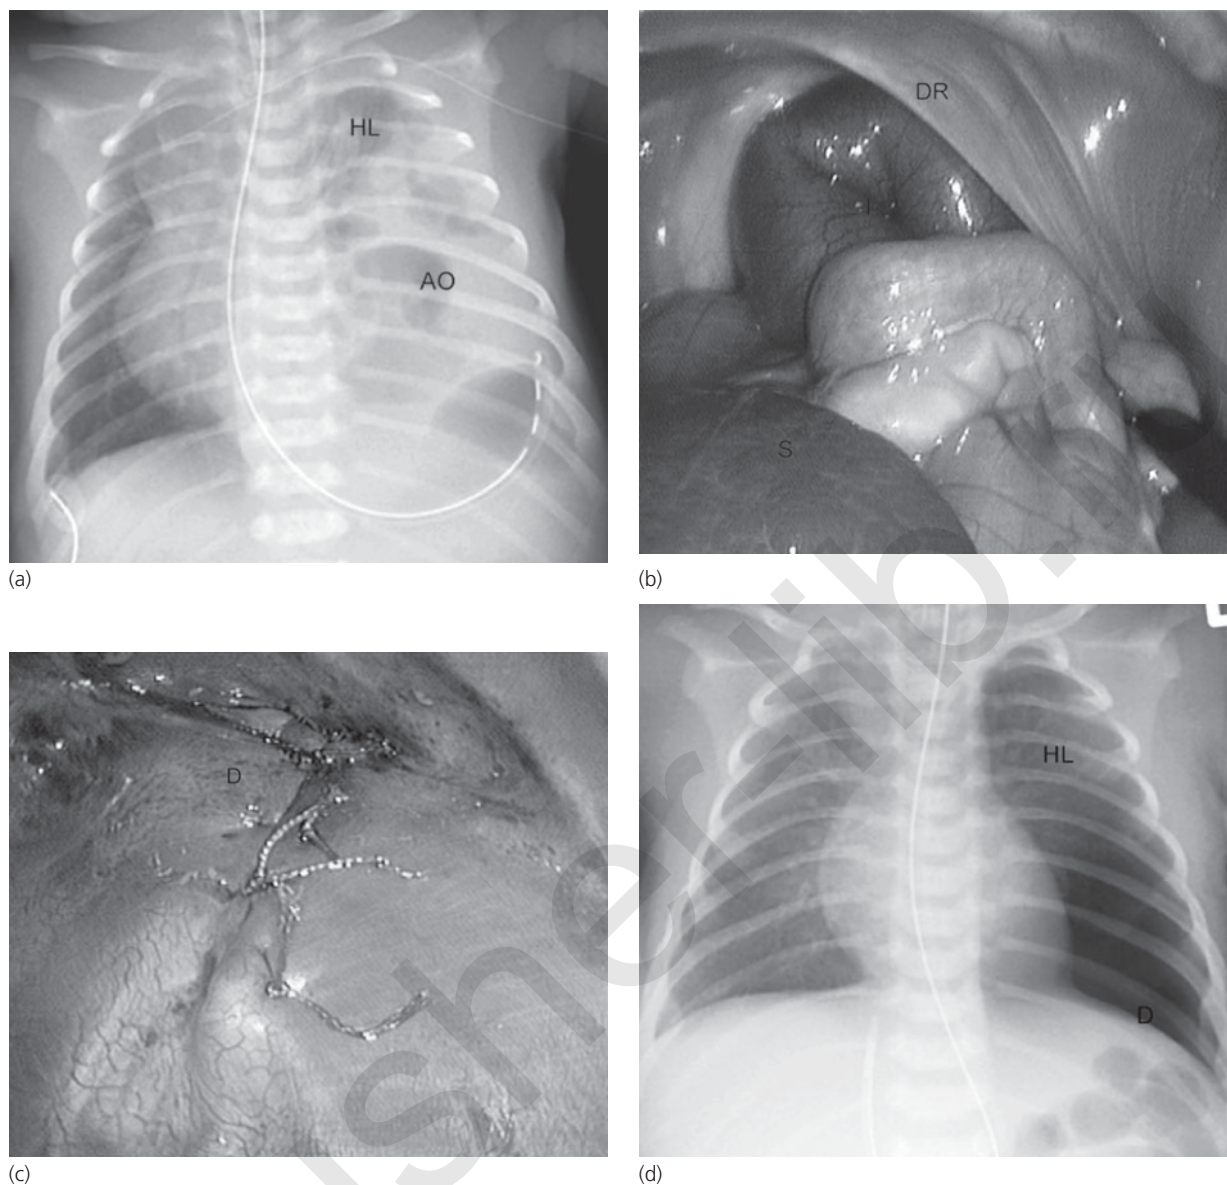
Closure of congenital diaphragmatic hernia (CDH): Preoperative chest x-ray of an infant with left-sided CDH (a). Thoracoscopic intraoperative view looking down on the abdominal organs (intestines and spleen) that herniated through the diaphragmatic defect into the thorax (b). Diaphragmatic defect has been closed using interrupted sutures (c). Postoperative chest x-ray. Note the hypoplastic lung in the top of the thorax and the reconstructed dome of the diaphragm (d). AO: abdominal organs; D: diaphragm; DR: diaphragmatic rim; HL: hypoplastic lung; I: intestines; S: spleen.
